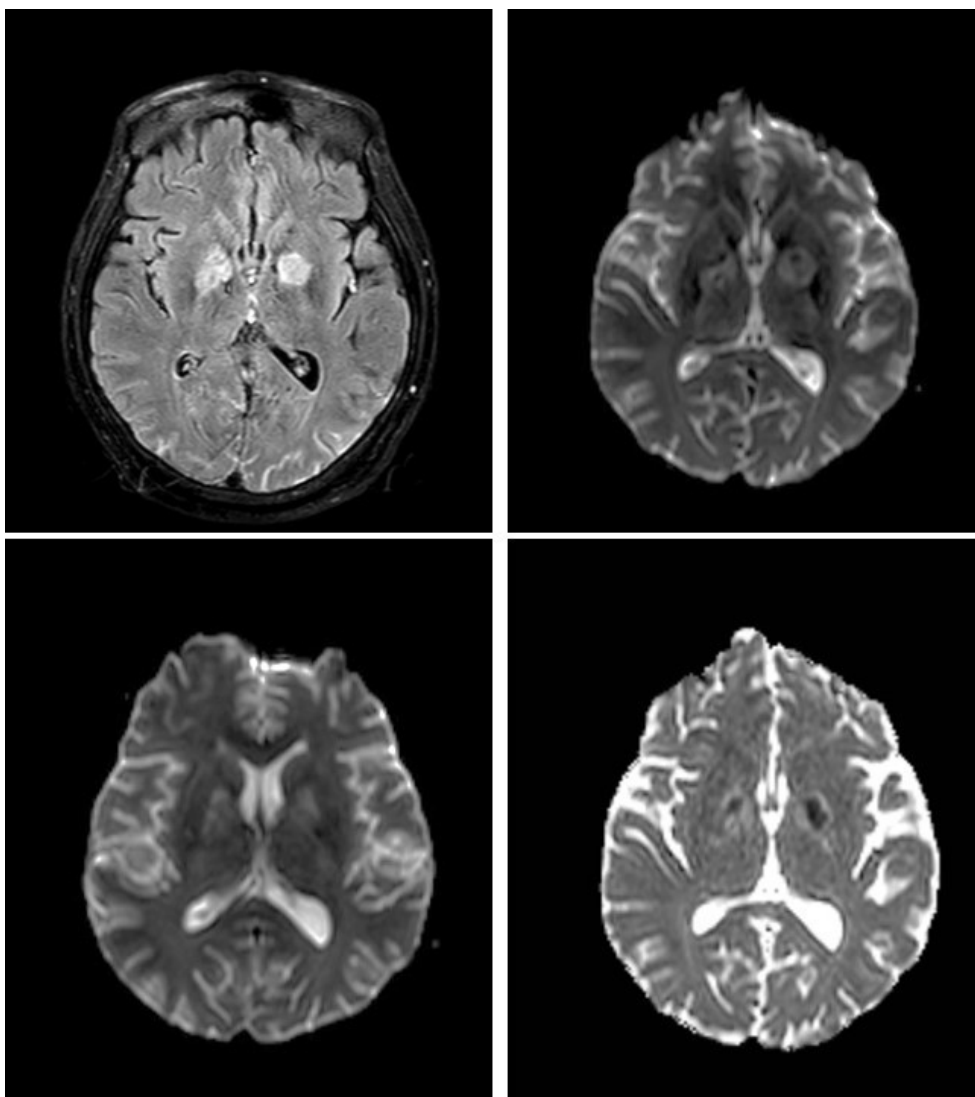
Magnetic Resonance Imaging of the head revealed bilateral hyperintense symmetrical basal ganglia lesion on Fluid Attenuated Inversion Recovery Imaging (upper left inset); with diffusion restriction of Diffusion Weighted Imaging (upper right inset; lower insets).
